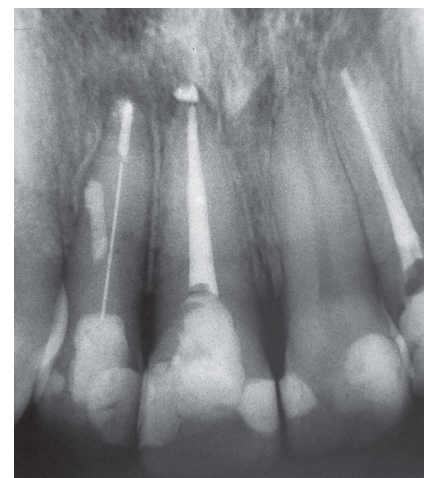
Follow-up radiograph after 6 months.
